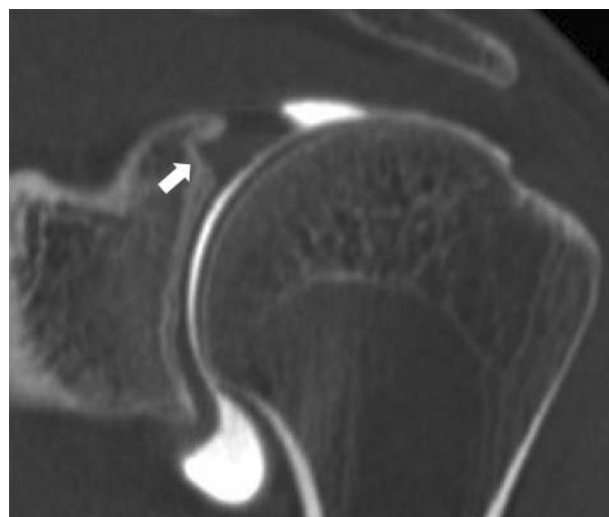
CT arthrogram 1 year after the operation demonstrated anatomical healing of the superior labrum to the bony glenoid (white arrow).
